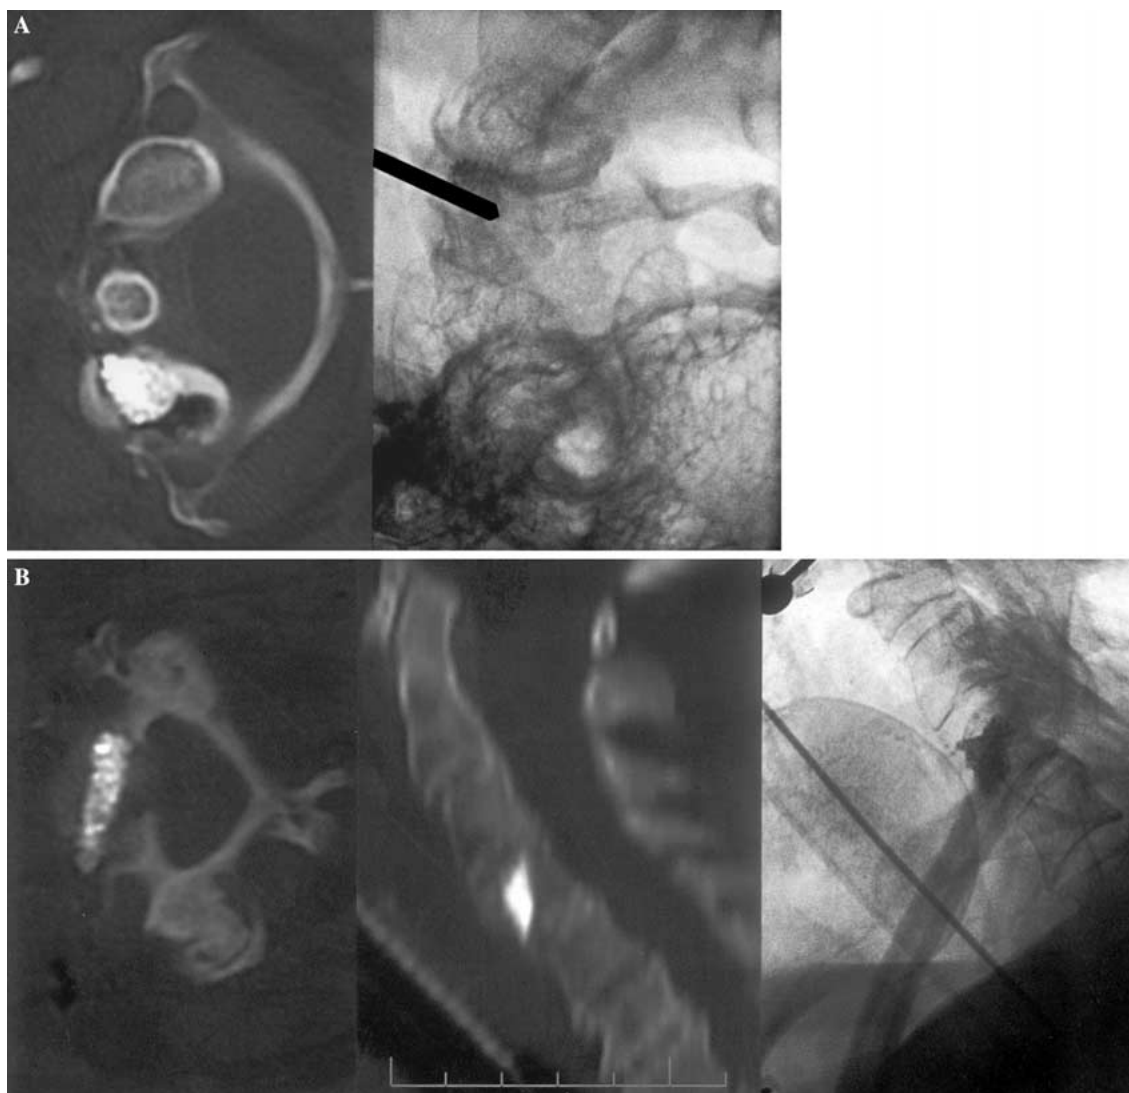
A. Fluoroscopy image during the filling process of the right C1 body lesion and axial computed tomography after vertebroplasty. The distribution of cement can be better appreciated on CT images than plain films. No leakage toward the vertebral artery can be observed.
